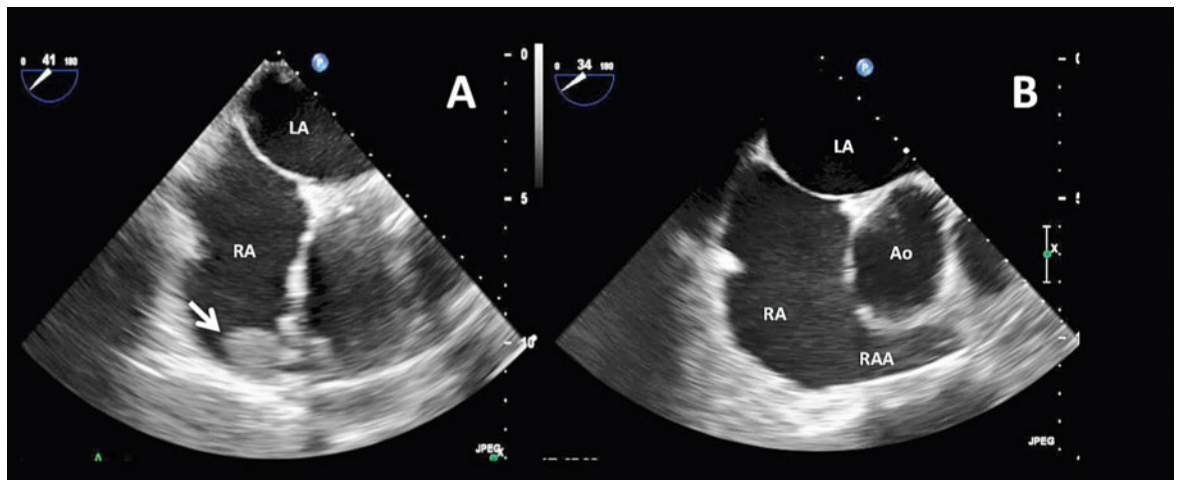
2-Dimension transoesophageal echocardiography, mid-oesophageal 40° view; (A) white arrow points at thrombus at time of presentation; (B) 3 months later after anticoagulation.
